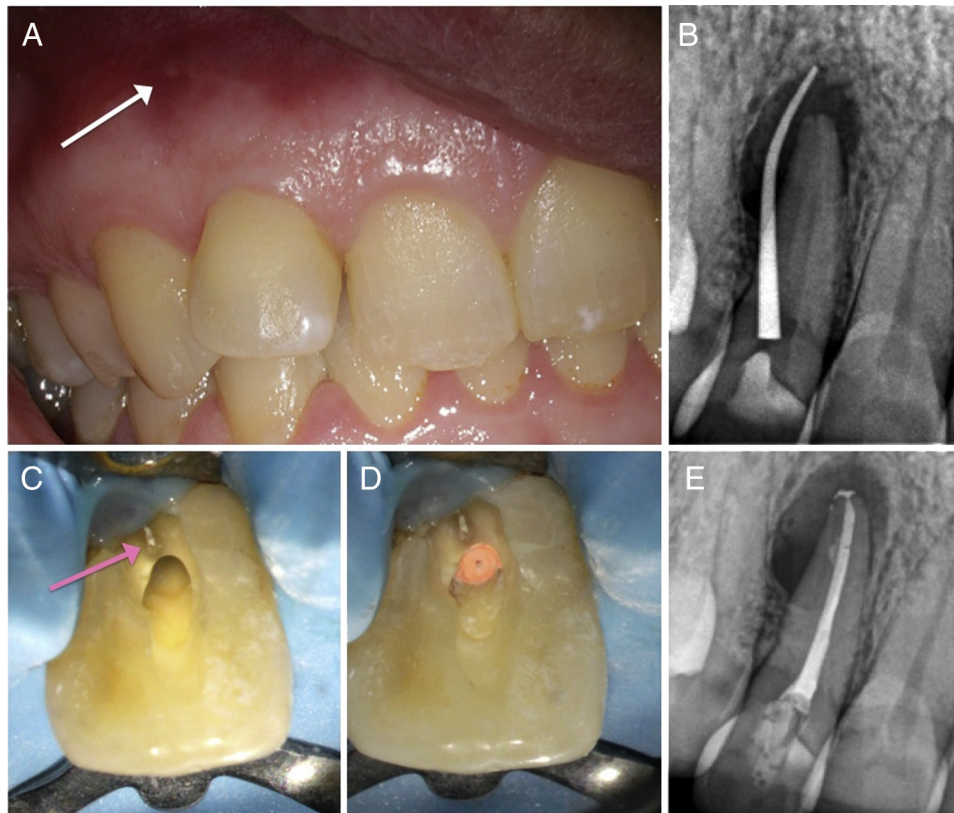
(A) The maxillary right lateral incisor (tooth #7). A preoperative clinical photograph showing a draining sinus tract (*white arrow*). (B) A periapical radiograph with a gutta-percha cone tracing the facial sinus tract to the periradicular radiolucency associated with tooth #7. Two narrow vertically oriented radiolucent lines were also evident within tooth #7. (C) Communication of the radicular groove (*pink arrow*) with the pulp chamber. (D) An image of the obturated root canal. (E) A postoperative radiograph.
